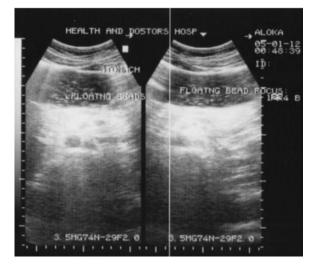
Ultrasonogram images of Formulation F3 at 3 hours.
